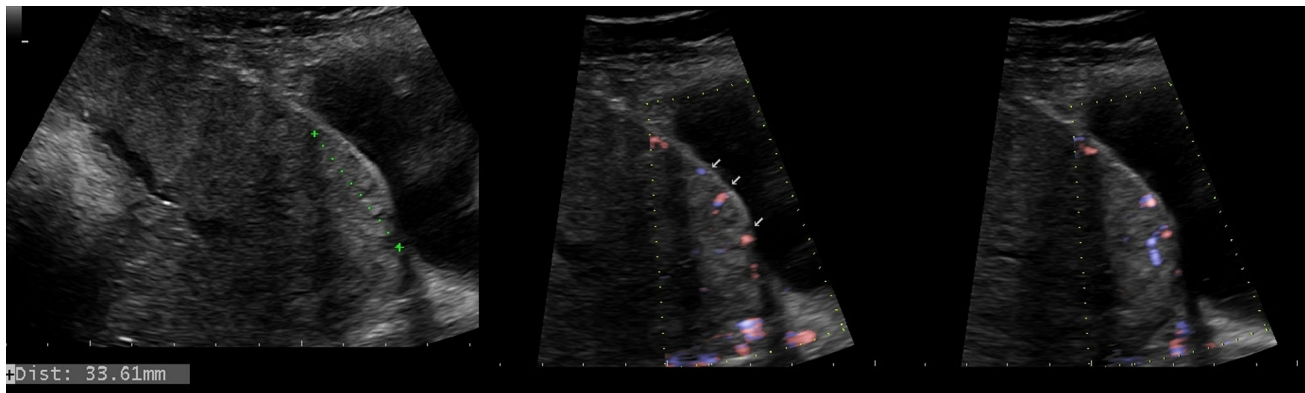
Case II: Abnormal trophoblast invasion with absence of hypoechoic zone and moth-eaten appearance in the intraplacental lacunae on Doppler suggestive of placenta accreta
